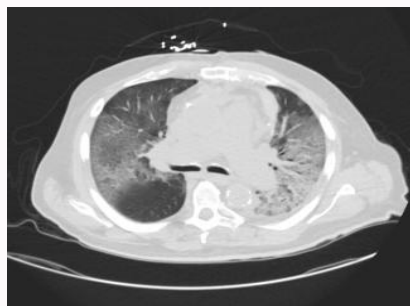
Axial thoracic computed tomographic image demonstrating bilateral ground glass opacities and interlobar septal thickening.
